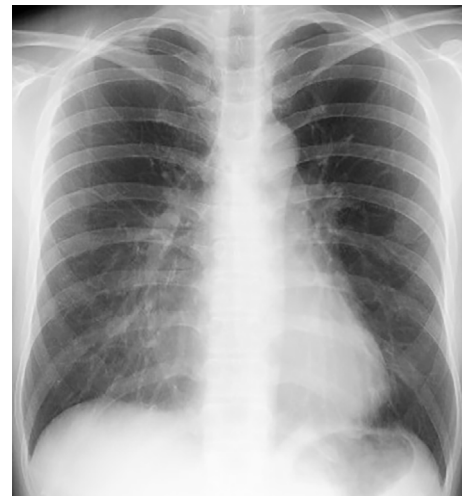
Plain chest radiography: Pleural effusion and cardiomegaly have disappeared.
